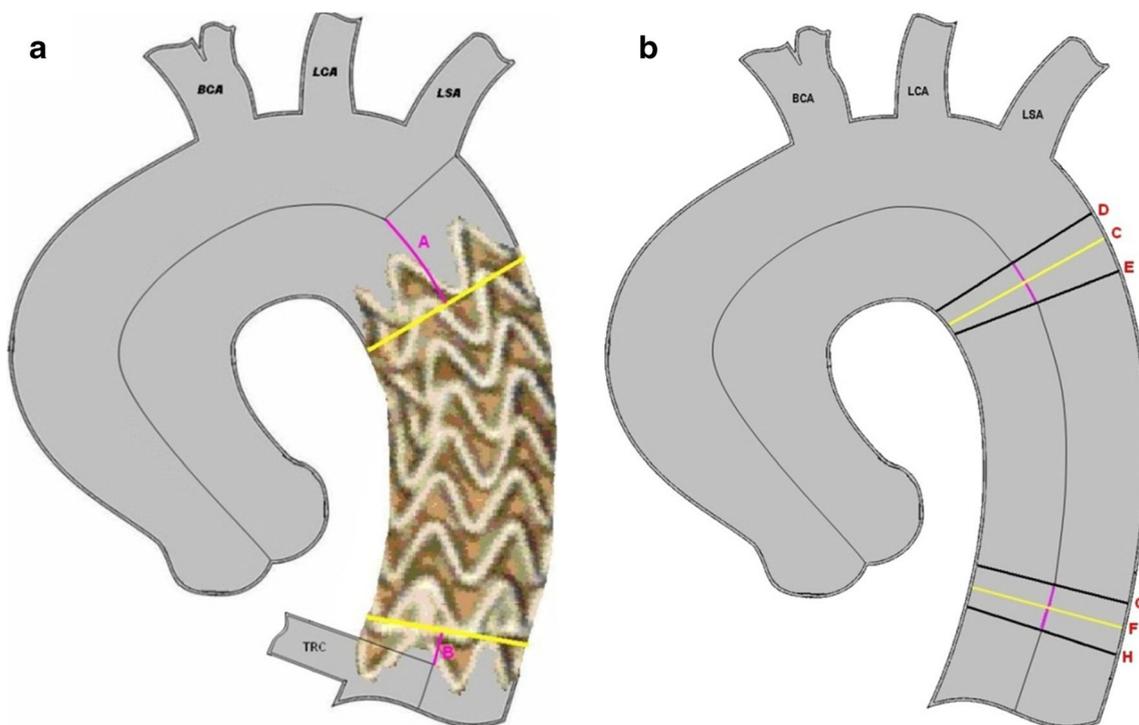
a Distance measurements between the proximal end of the stent-graft and the ostium of the left subclavian artery (LSA) (A), as well as between the distal end of the stent-graft and the ostium of the coeliac trunk (TRC) (B) based on the first postoperative CT angiography. BCA brachiocephalic artery, LCA left carotid artery. b The maximal aortic
